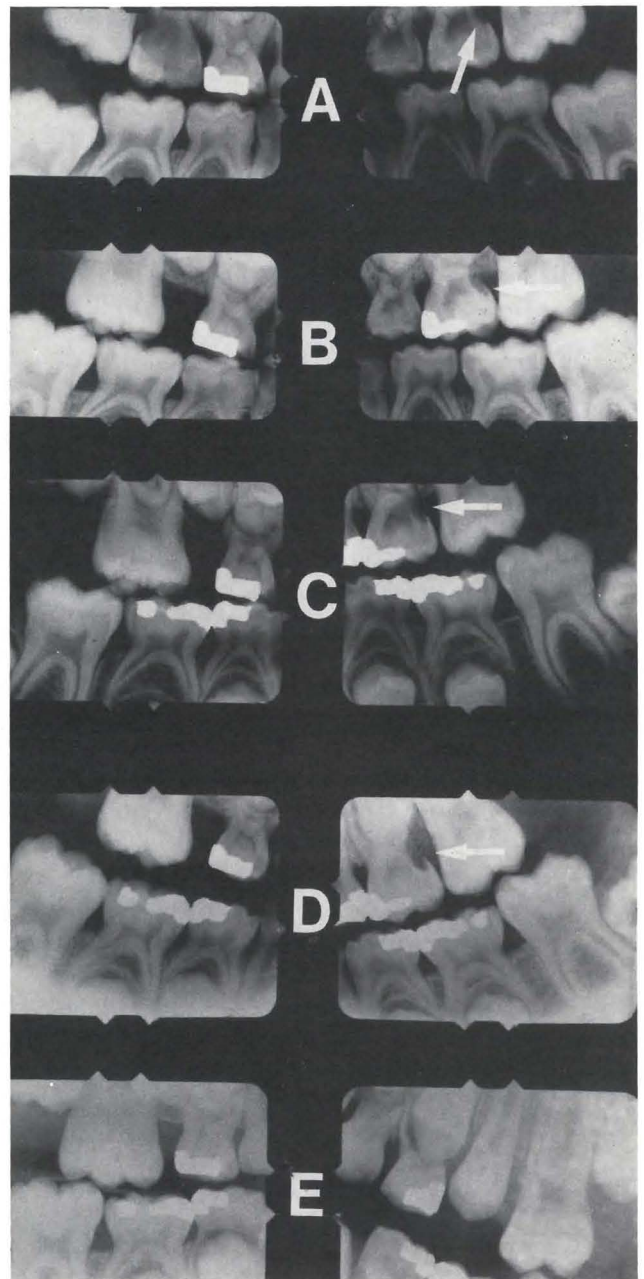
A series of radiographs from primary through to permanent dentitions. (A) Bitewing radiographs of 5.5-year-old show no signs of ectopic eruption on either side. (B) Signs of resorption on distal root of upper left second primary molar were observed, following first molar eruption. (C) One year later, severe resorption of the left primary molar is found and resorption in the primary molar on the right side was first noticed. (D) Space maintainer is in place. Minimal space loss occurred and resorption on the right side appeared arrested. (E) All premolars are in occlusion.
